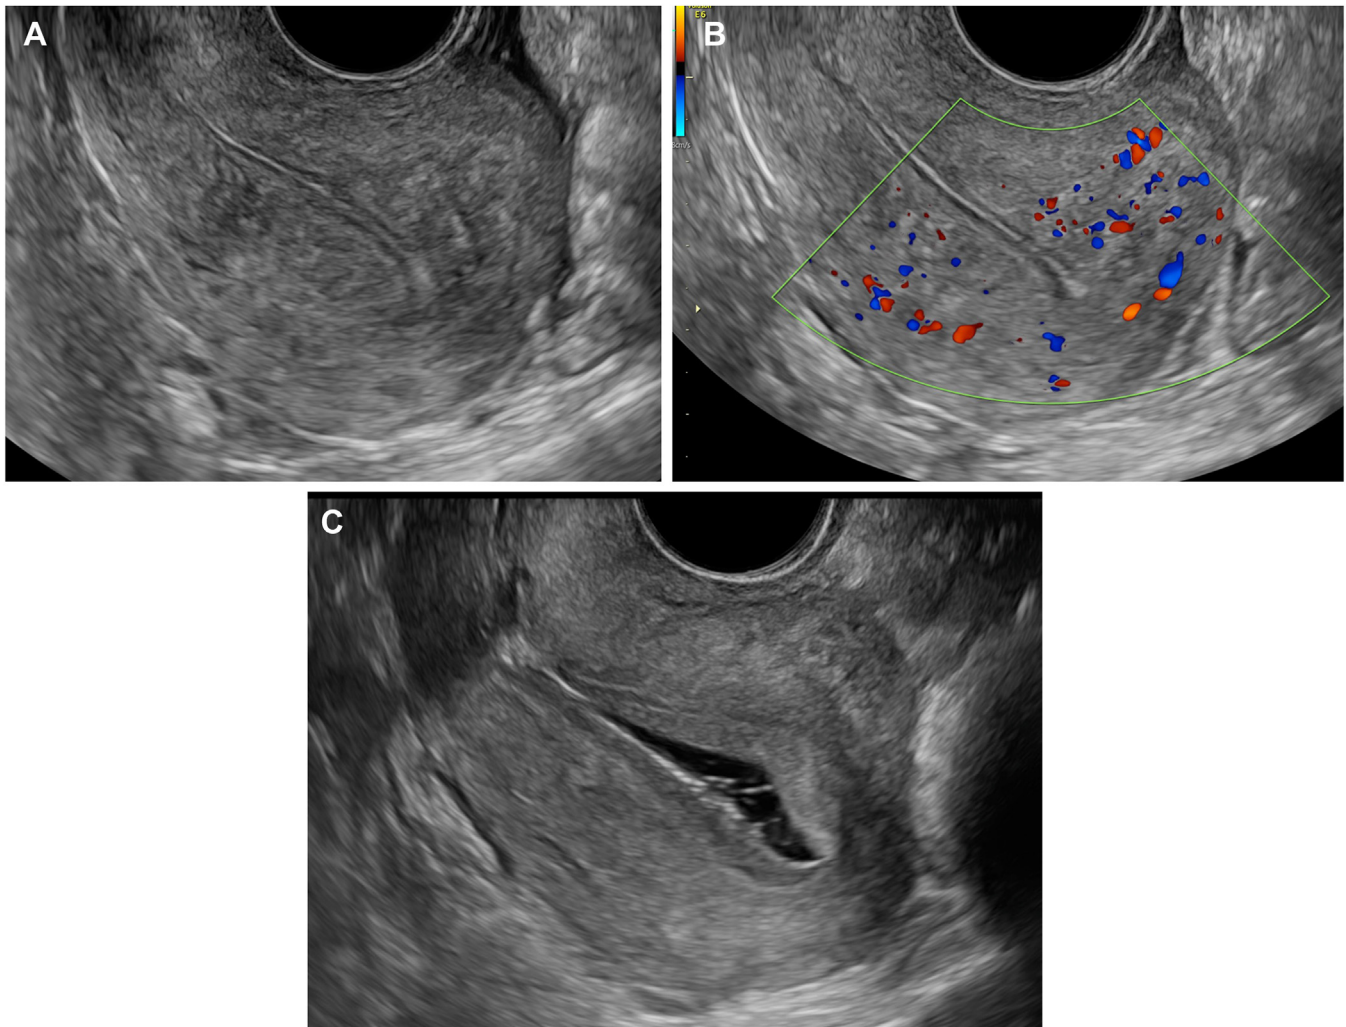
Pelvic Ultrasound. *A* and *B*: Retroverted uterus with inhomogeneous myometrial echotexture and indistinct endometrial stripe = diffuse adenomyosis. Increased vascularity of myometrium. *C*: Post Rx. Homogeneous myometrial echotexture with smooth endometrial-myometrial interface
